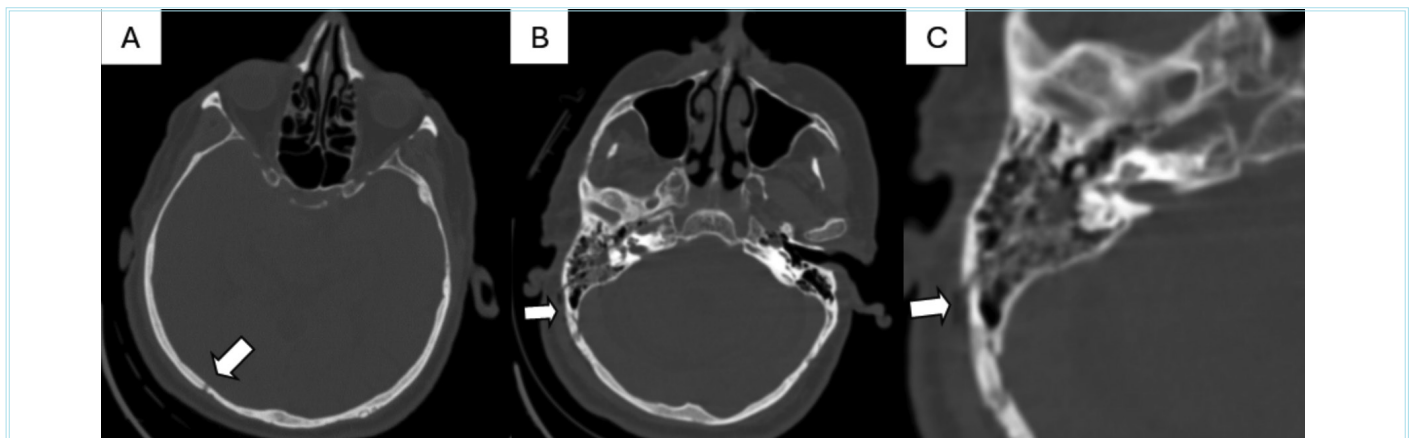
A 69-year-old male patient. Occipital fracture in axial computed tomography images (A, arrow) and temporal bone mastoid segment linear nondisplaced fracture in axial computed tomography images (B, C, arrows)
